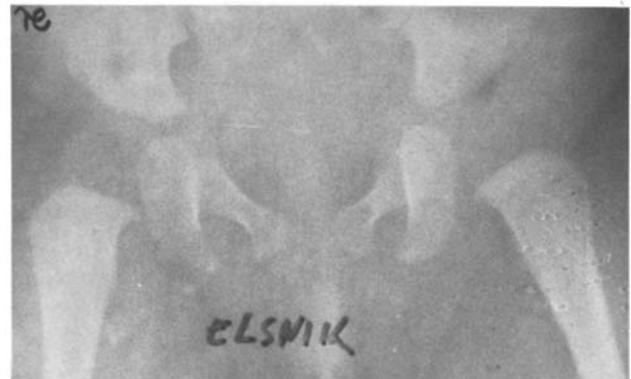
Radiograph to Fig. 2a in comparison, lateral position
